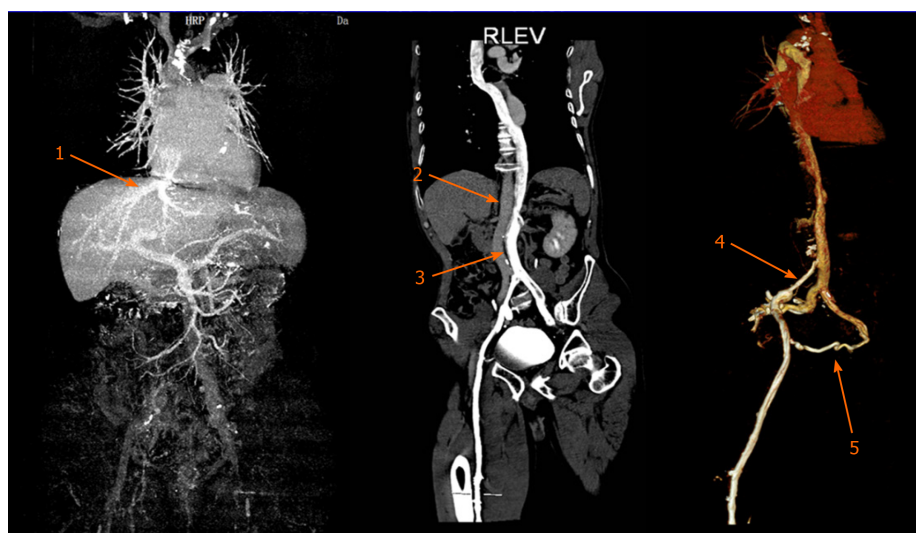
Contrast-enhanced computed tomography revealing a case of left-sided inferior vena cava draining into the hemiazygos vein with the hepatic vein directly draining into the atrium. 1: The hepatic vein directly draining into the atrium; 2: The abdominal aorta; 3: The left-sided inferior vena cava; 4: Right iliac vein stenosis; 5: Collateral vessels.
